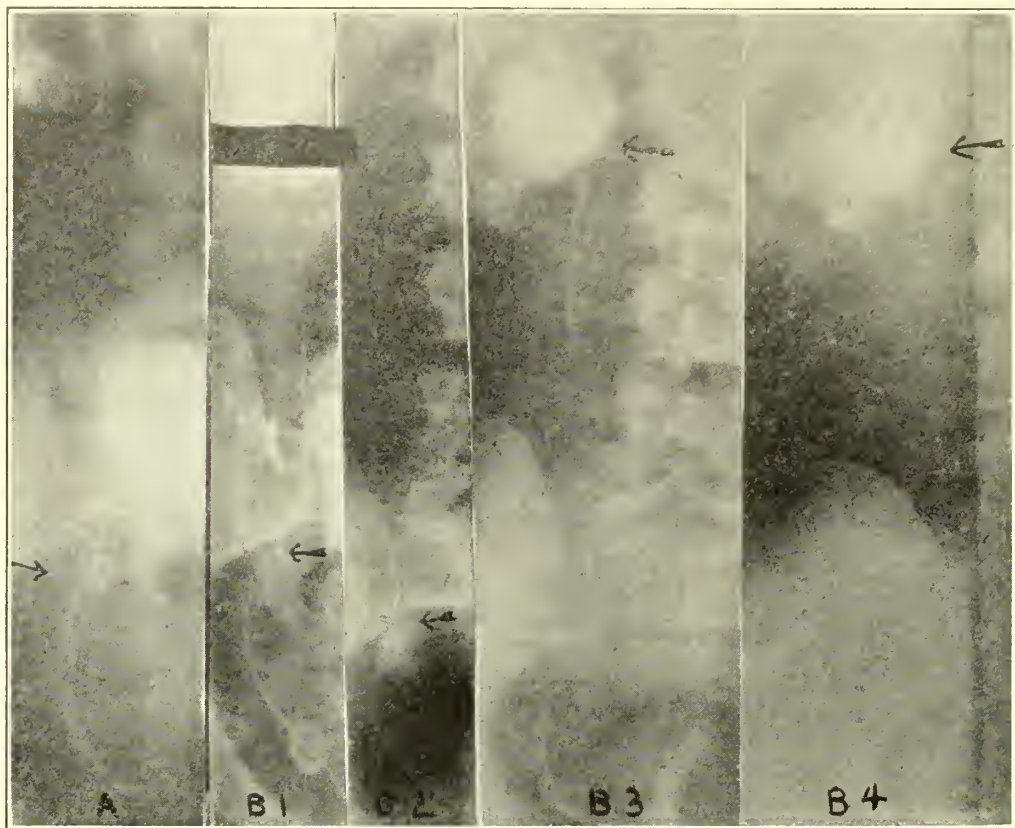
A. Double exposed film with shifting of X-ray tube. Note that stone shadow is in same relation to catheter in each instance.
